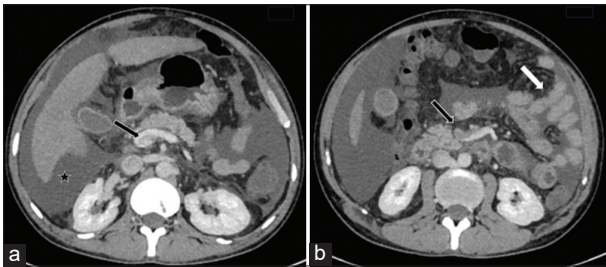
Computed tomography imaging demonstrating portal vein thrombosis with extension to the splenic vein and superior mesenteric vein, along with ascites formation. (a) Demonstrates non-opacification at the confluence of the portal and splenic veins (black arrow), along with gross ascites (star); (b) Shows non-opacification of the superior mesenteric vein (black arrow) and edematous jejunal loops (white arrow), suggestive of mesenteric venous thrombosis with associated bowel wall edema
